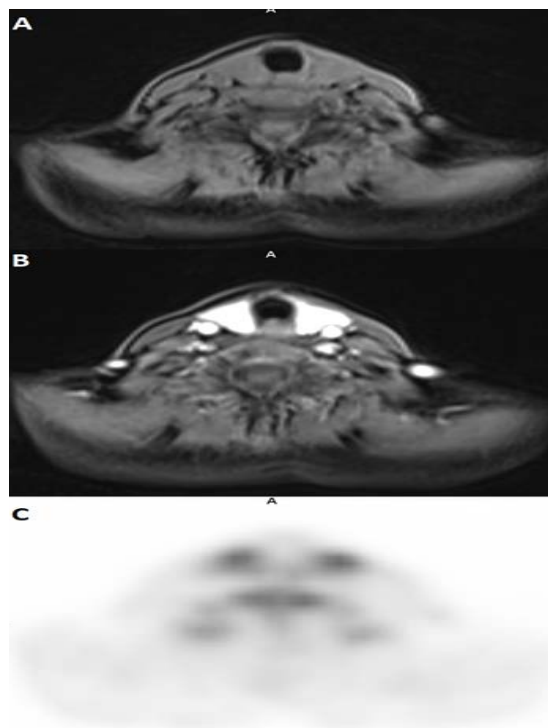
Images of the thyroid on pre-contrast T1 MRI (A), post contrast T1 MRI (B) and PET (C) demonstrating the intense contrast enhancement, comparable to vascular structures corresponding to diffuse FDG uptake throughout the thyroid gland consistent with thyroiditis.
